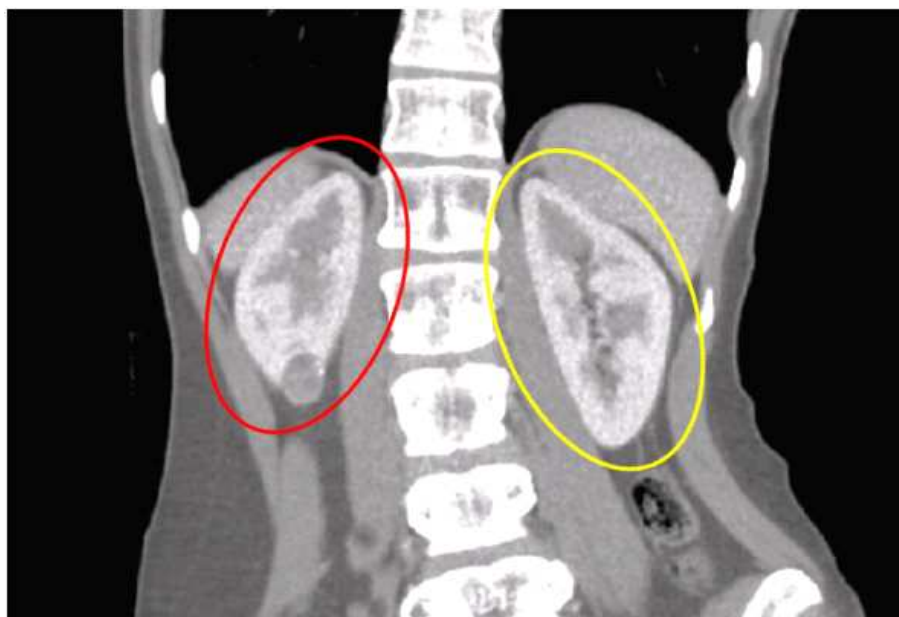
CT angiogram from a human patient showing the healthy left kidney on the right side of the image and the tumorous right kidney on the left.
